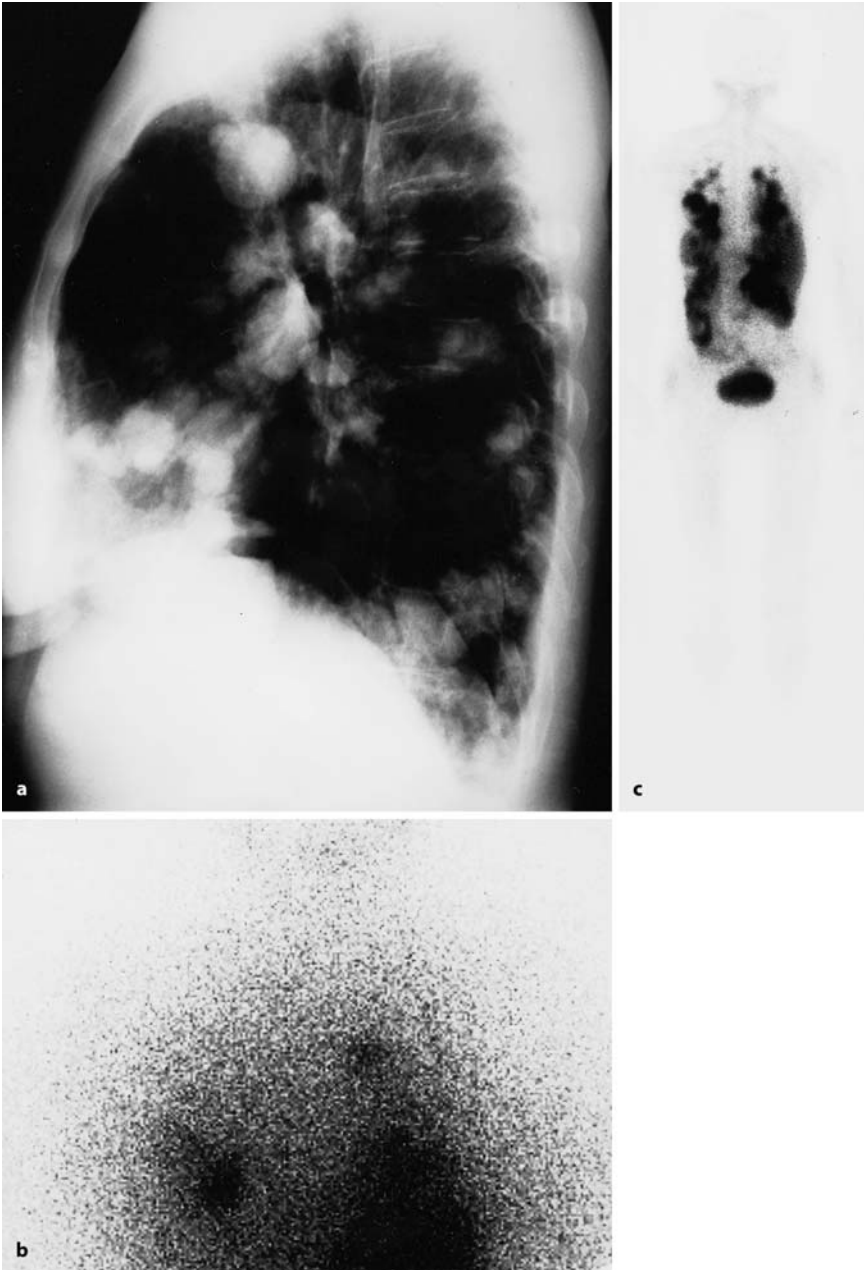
a-d A 71-year-old female patient with Hürthle cell thyroid cancer and multiple lung metastases. The X-ray appearance is shown in a. Whole-body scintigraphy with radioiodine (dorsal view) shows faint uptake at one pulmonary site (b). Whole-body MIBI scintigraphy (dorsal view) (c) and SPECT imaging with MIBI (d) show high tracer uptake in the pulmonary metastases
